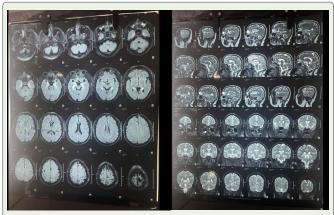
MRI Brain with T2 hyperintense / FLAIR seen involving the bilateral mesial temporal lobes including amygdala, hippocampi, parahippocampal gyri.
